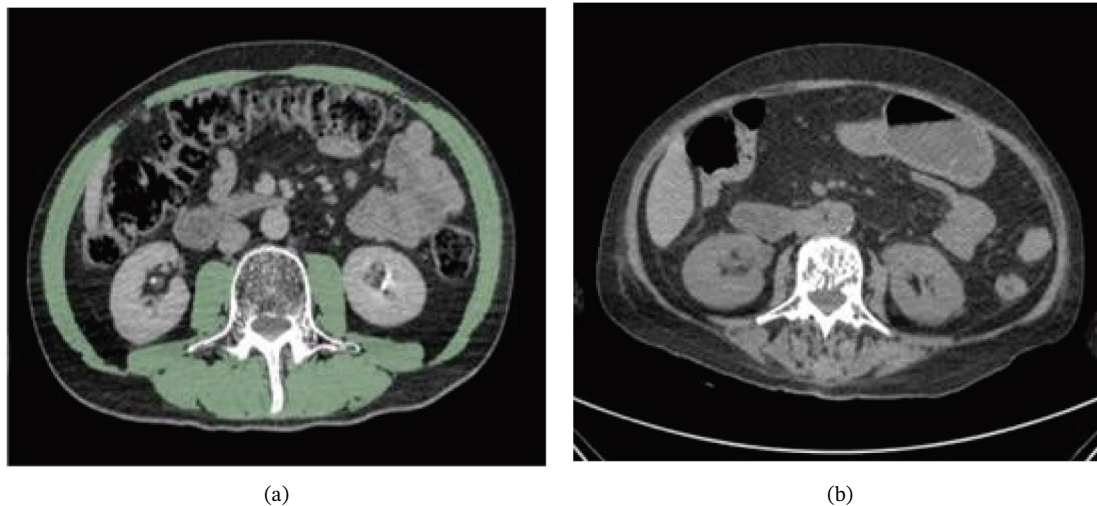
Example of muscle area evaluated on CT in non-sarcopenic MM patient (a) and sarcopenic MM patient (b). The green lined area contained psoas, paraspinous muscles and abdominal wall muscles at the level of third lumbar vertebra.
